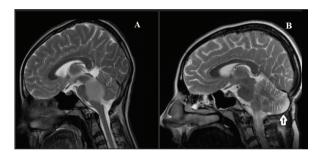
A demonstrative case with cerebellar ectopy. A. Pre-operative cranial sagittal MRI, B. Post-operative cranial sagittal MRI (white arrow: cerebellar ectopy)
